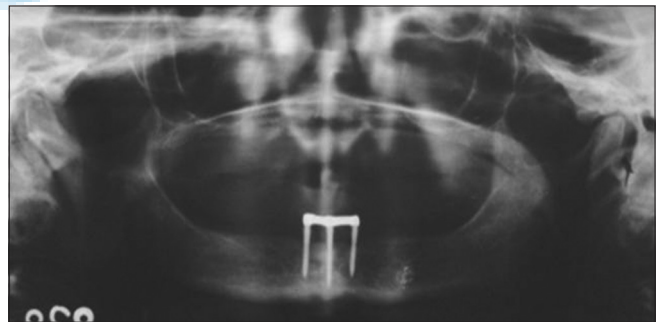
Orthopantomogram showing the splinted mini implants after osseointegration phase
